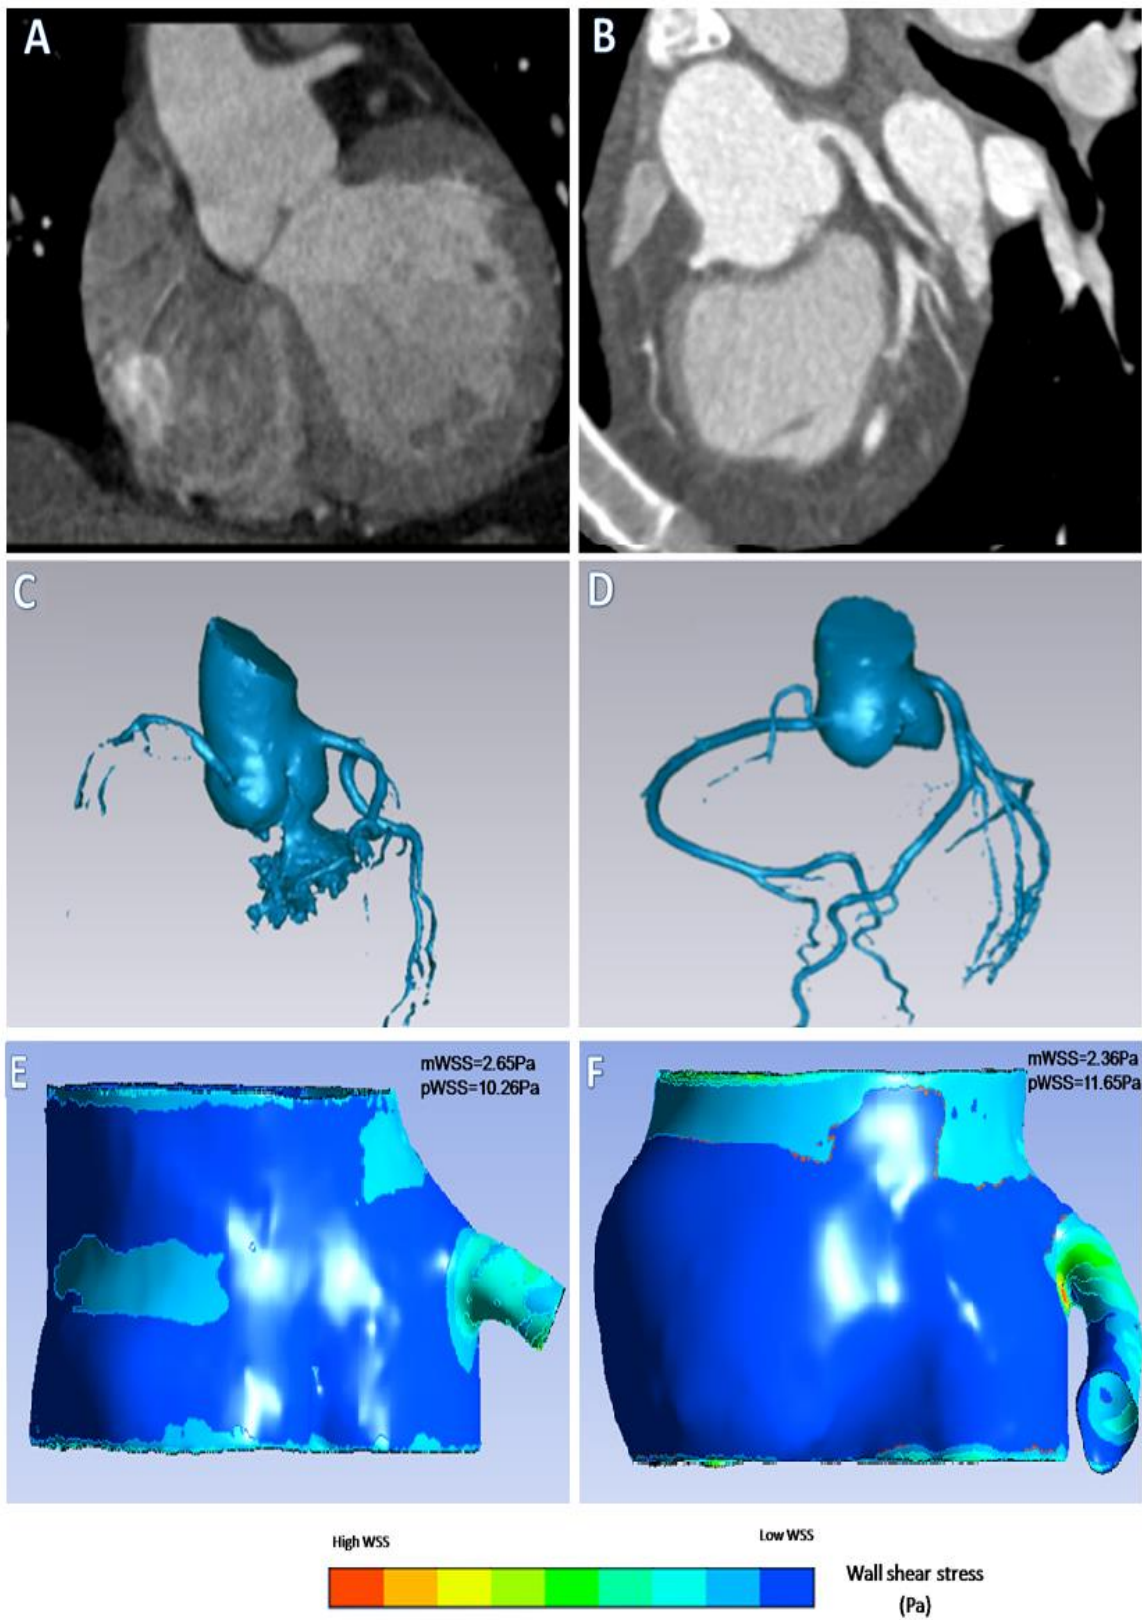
Representative CT Coronary Angiogram Images with Corresponding 3D Reconstruction of the Proximal Aorta and Coronary Arteries and Wall Shear Stress Mapping (WSS) Map. Sagittal CT Images of patient left main coronary artery (LMCA) for (A) Patient A who had 25° LMCA angulation and (B) Patient B who had 58° LMCA angulation. (C-D) Corresponding 3D reconstructed model images of patients. (E-F) Corresponding WSS maps.
